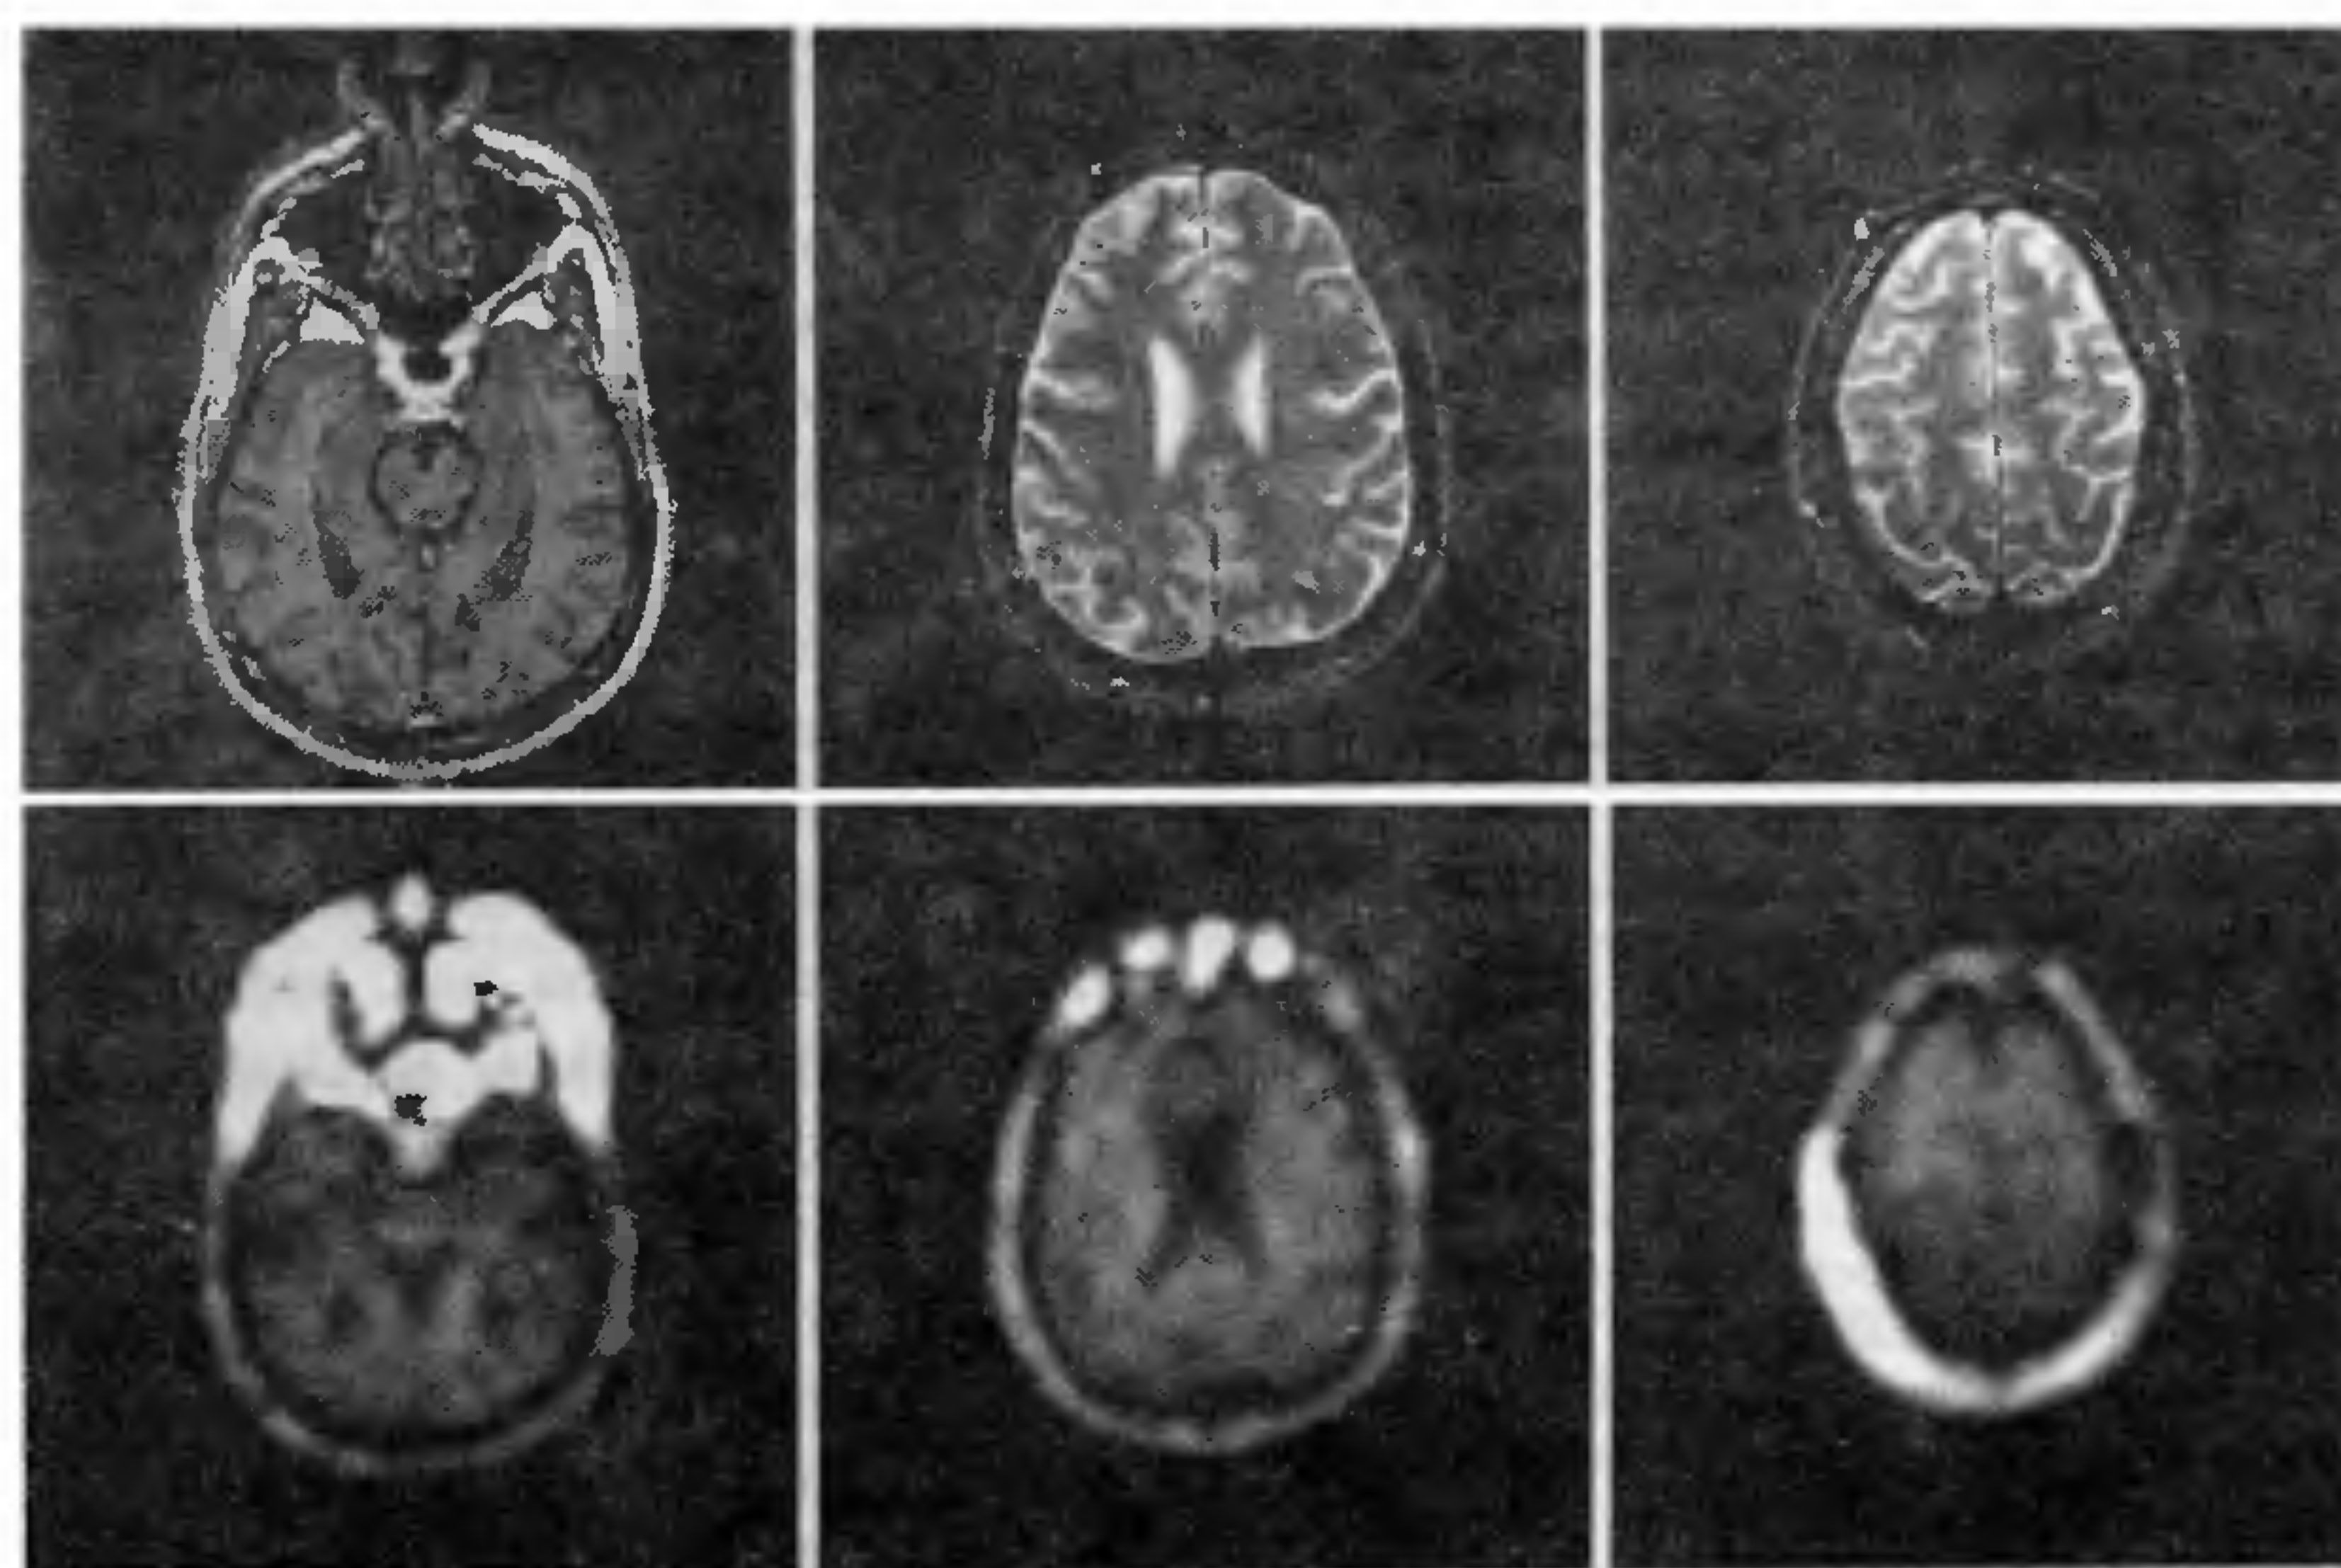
Representative NAA metabolite images (bottom) from a multislice ^1H MRSI study on a patient with temporal lobe epilepsy and the corresponding anatomical MR images (top). The orientation of the slices was selected to cover regions in the frontal, parietal, and temporal lobes, including both hippocampi.
